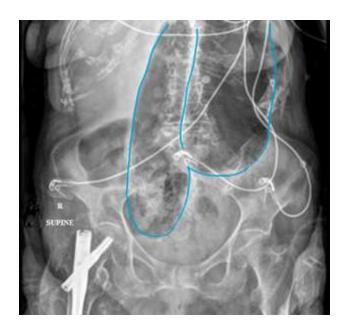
Abdominal radiography demonstrating an inverted U-shaped, distended colon consistent with sigmoid volvulus exhibiting the classic "coffee-bean sign" (blue outline). Surprisingly, the apex of that sigmoid loop was obscured.
